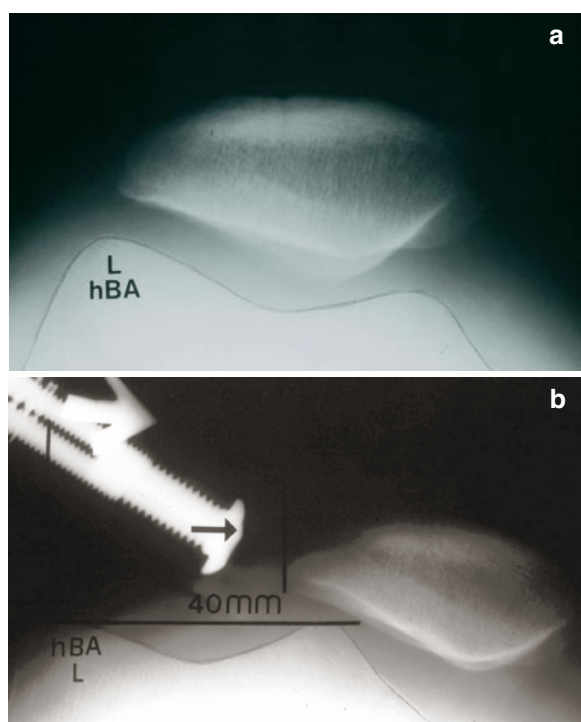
(a) Axial view of patella in patient with “dashboard injury” much worse after lateral retinacular release. (b) Stress radiograph of the PF joint shows complete medial dislocation of the patella and when compared with the opposite normal knee a 24 mm increase in medial excursion
